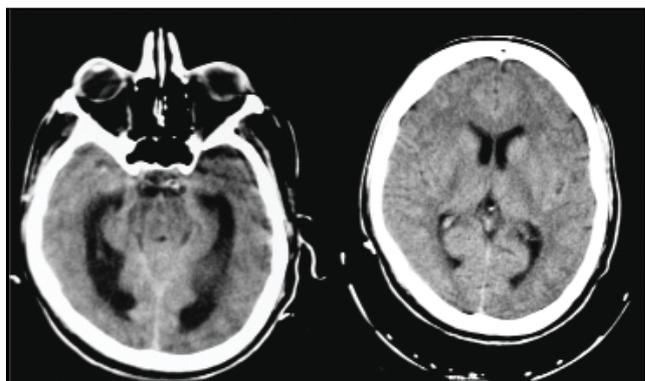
The patient's brain CT scan taken after 24 hours
